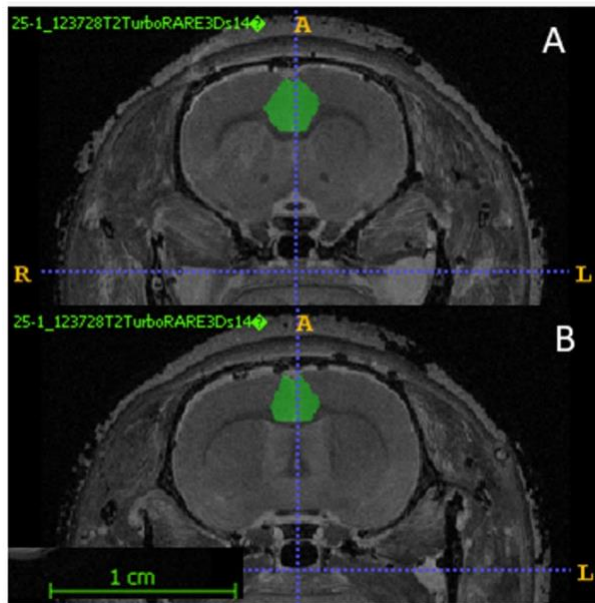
MRI of frontal cortex region. A) coronal view at +2.16 from bregma showing start of ACC and, B) shows end of ACC at -.60 mm from bregma.
